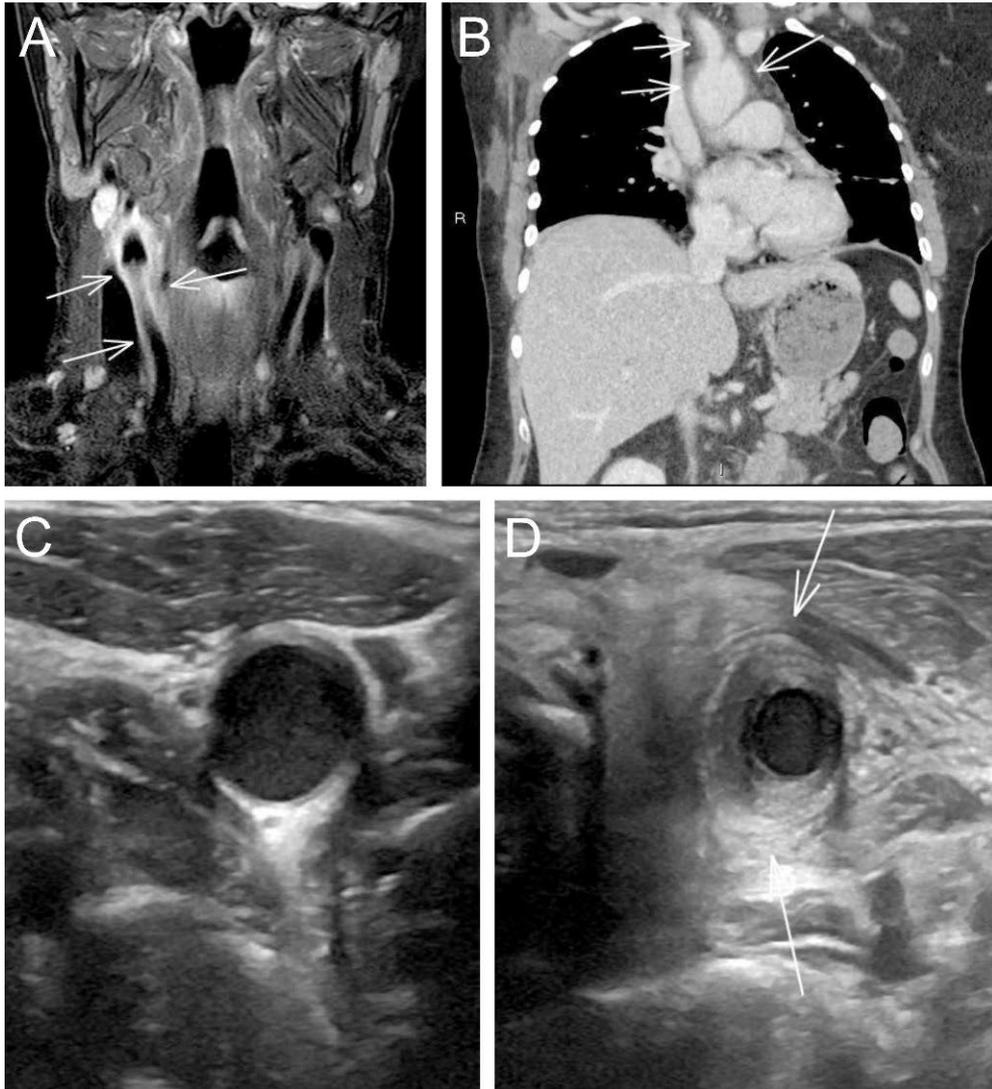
Different imaging techniques showing inflammation of the carotid artery and aorta. A. MR imaging showing perivascular increased signal intensity around the right common carotid artery (CCA). B. CT shows diffuse wall thickening in the thoracic aorta and in the arteries ascending from the aortic arch C. US imaging of both CCA showing normal right CCA and D. pathologic left CCA with a hypoechoic and thickened wall.
